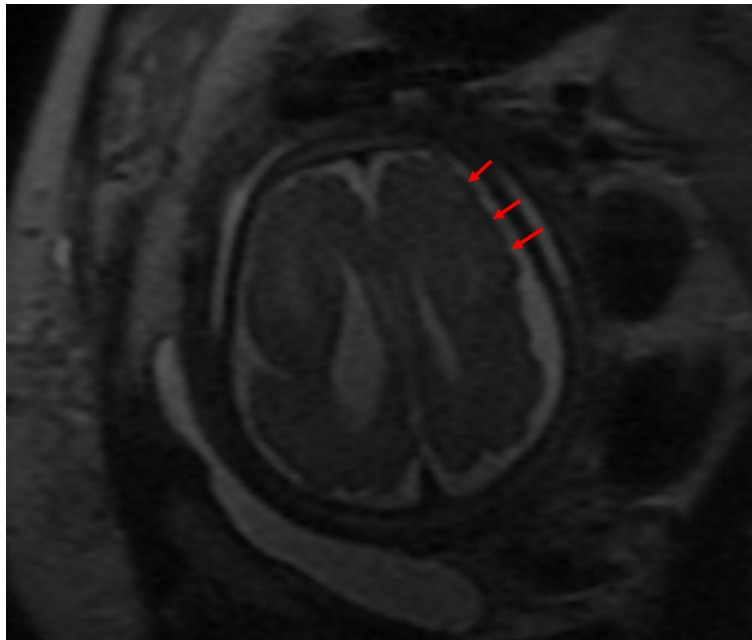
Coronal SSFSE T2 fetal MRI demonstrates questionable pachygyria in the left frontal cortex (red arrows). “Color version available online.”
